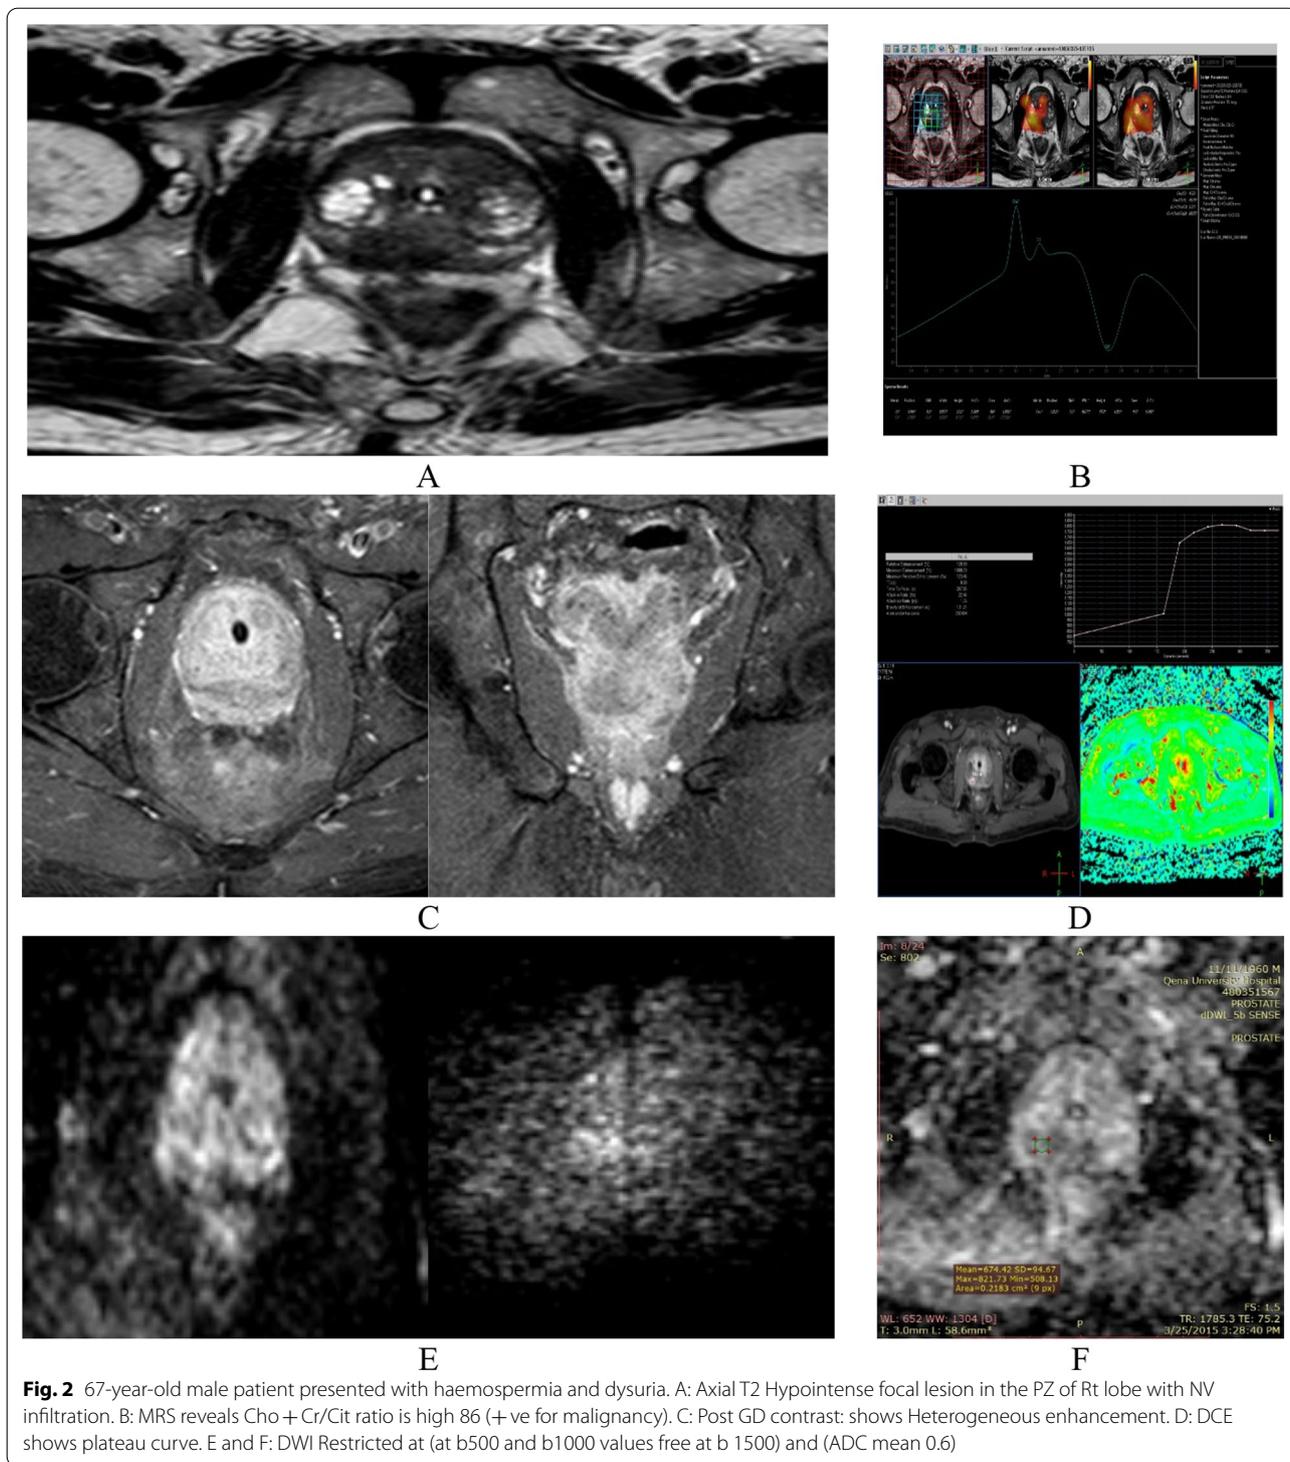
67-year-old male patient presented with haemospermia and dysuria. A: Axial T2 Hypointense focal lesion in the PZ of Rt lobe with NV infiltration. B: MRS reveals Cho + Cr/Cit ratio is high 86 (+ve for malignancy). C: Post GD contrast: shows Heterogeneous enhancement. D: DCE shows plateau curve. E and F: DWI Restricted at (at b500 and b1000 values free at b 1500) and (ADC mean 0.6)
